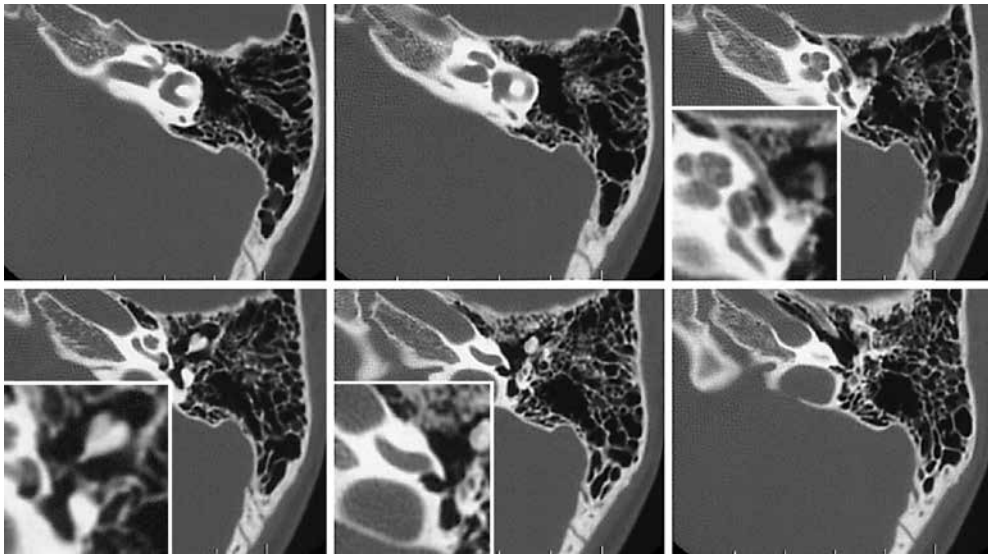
Left temporal bone CT of a patient with unilateral microtia and atresia. The temporal bone is well developed.
